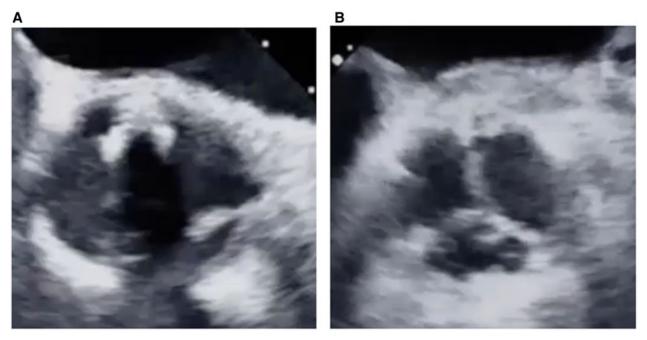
(A) Preoperative transoesophageal echocardiography. (B) Intraoperative transoesophageal echocardiography. TEE: transoesophageal echocardiography
